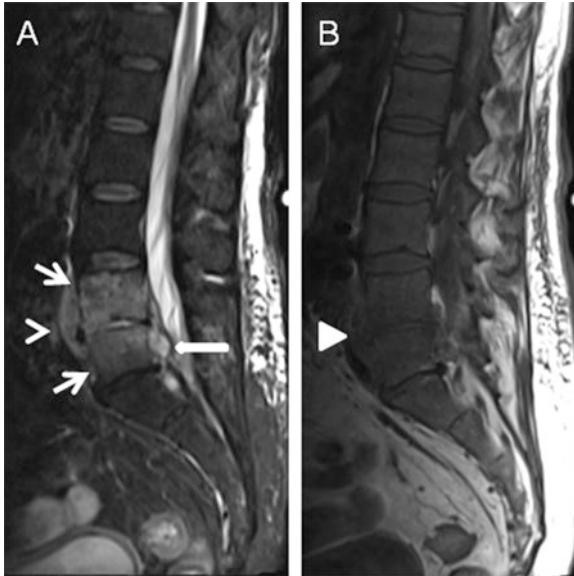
Spondylodiscitis. On the pretreatment sagittal STIR MRI image of the lumbar spine (a), there is L4-L5 disc space narrowing and edema with L4 and L5 vertebral body edema (arrows). There are fluid collections in the paravertebral region (arrowhead) and anterior spinal canal (solid arrow). On the sagittal noncontrast T1 MRI image of the lumbar spine (b), there is corresponding decreased signal in the L4 and L5 vertebral bodies and L4-L5 disc space (solid arrowhead). Biopsy confirmed acute osteomyelitis with paravertebral abscess and ventral epidural abscess
